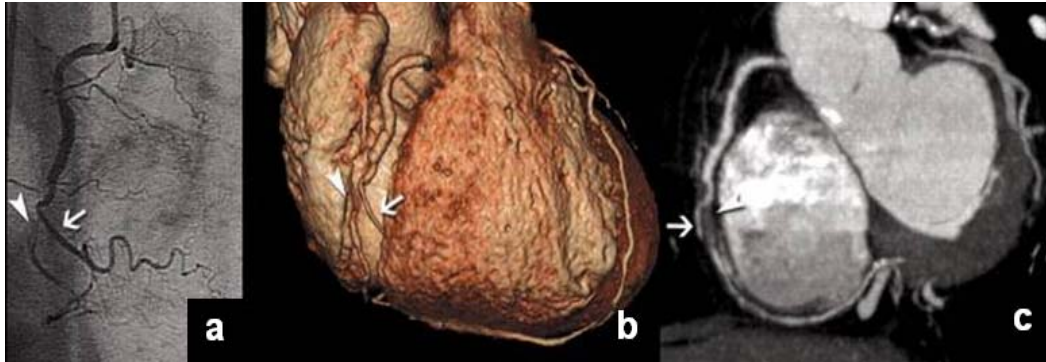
MSCT Imaging. (Arrow head points to an occlusion and arrow points to RV branch of the RCA.) (a) conventional angiography image; (b) corresponding volume rendered CT image; (c) CT of maximum intensity projection [14].
